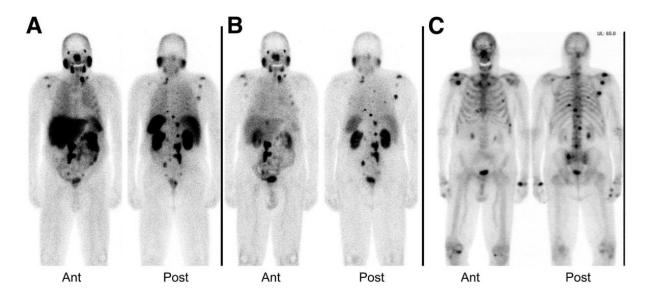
Comparative SPECT imaging of ^{99m}Tc-MIP-1404 (A) or ^{99m}Tc-MIP-1405 (B) in the same patient with metastatic PCa (4 h p.i.), in comparison to standard bone scan (C). Figure was originally published in JNM 2014 [185] © SNMMI, Vallabhajosula S, *et al.* Available from: http://jnm.snmjournals.org/content/55/11/1791.
